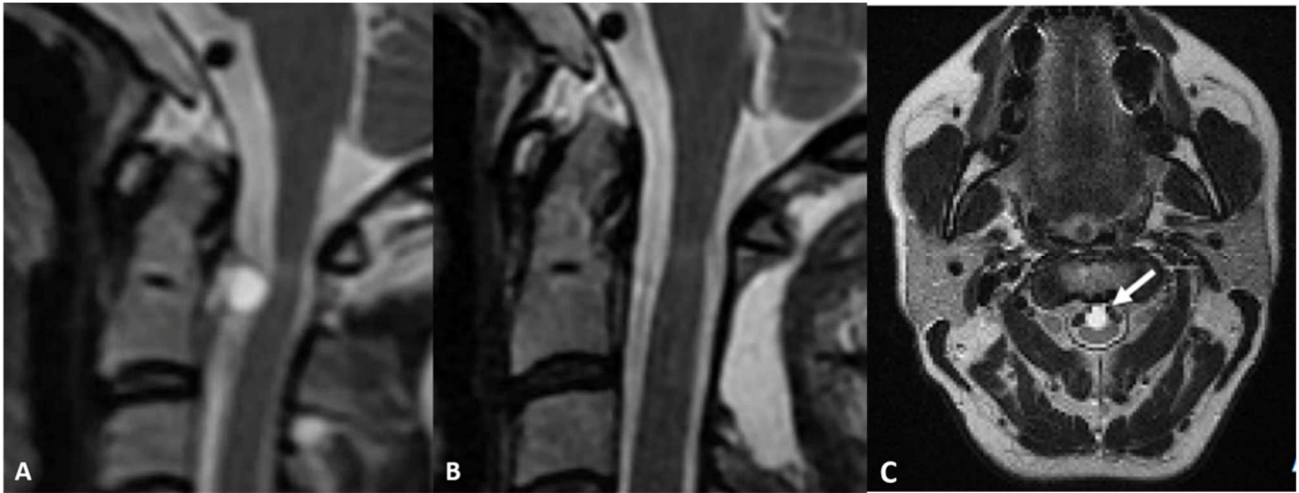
Sagittal T2 MRI. A hyper-intense cyst with spinal cord compression and intramedullary hyper-intensity is seen and follow-up after 4 years. The patient was pain free, with no clinical or radiographic evidence of recurrence/instability
